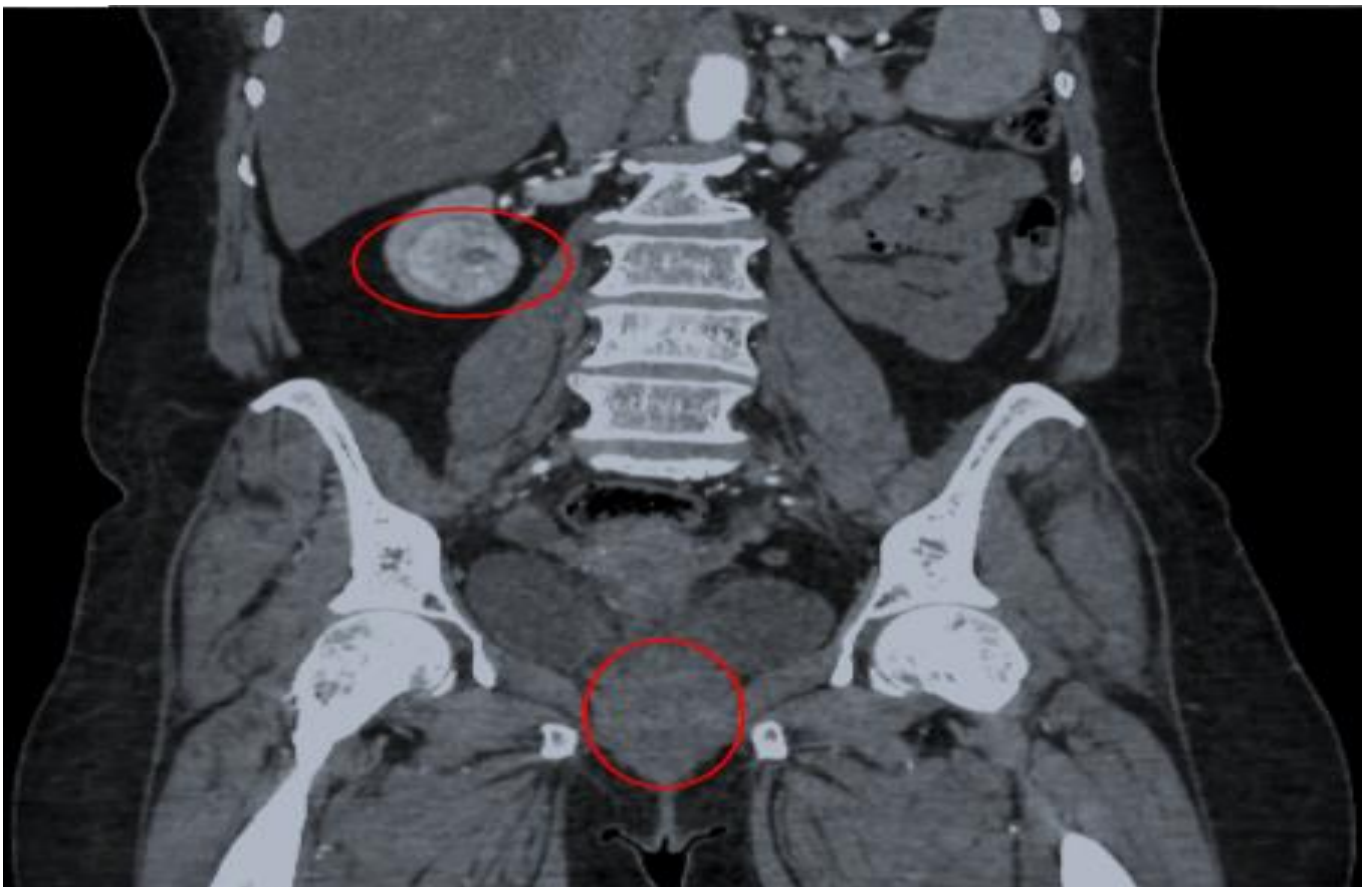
Coronal Section of Contrast Enhanced CT Scan Shows Right Renal Lesion and Cervical Lesion (Encircled).
